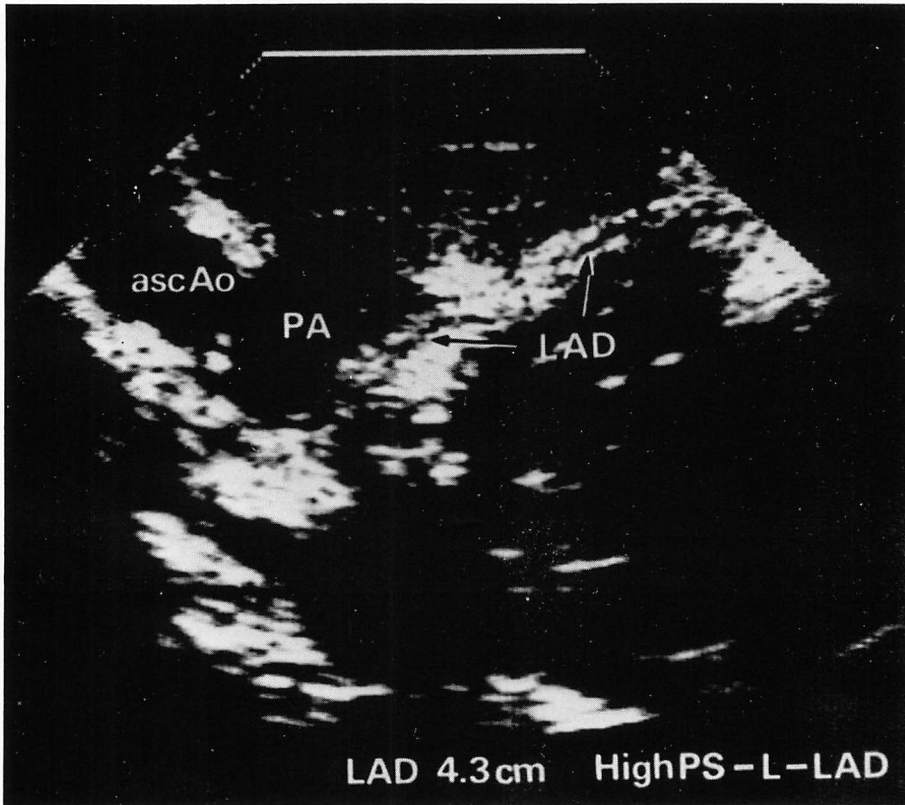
Representative echogram of the LAD recorded by the high-parasternal approach.
